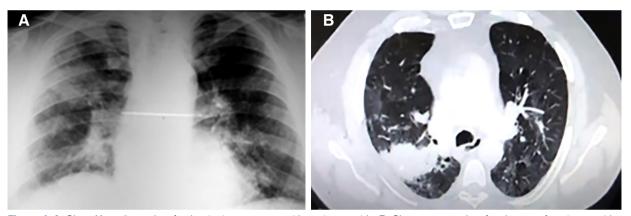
A. Chest X-ray 2 months after beginning treatment with corticosteroids. B. Chest tomography after the use of corticosteroids.
